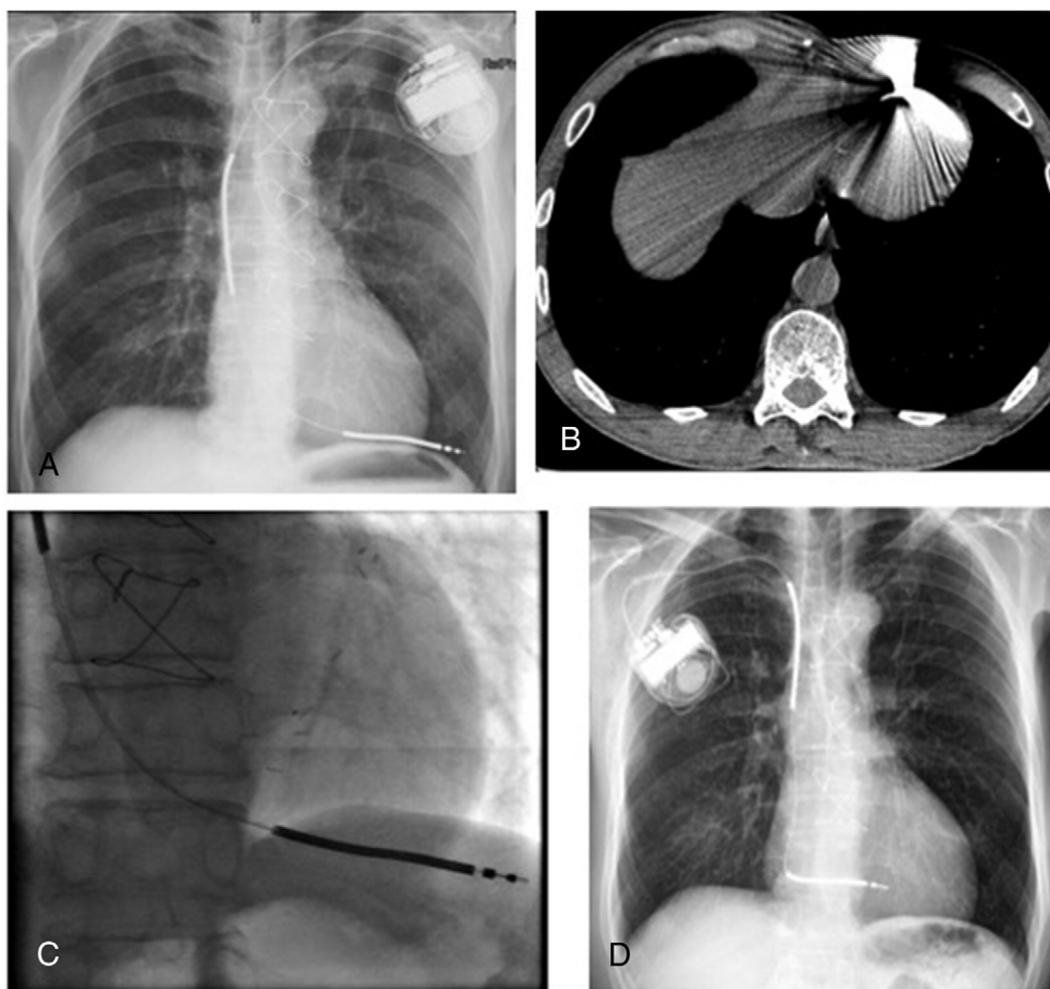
(A) Chest x-ray demonstrating RV perforation by ICD lead. (B) Computed tomography confirmed RV-lead perforation. (C) Fluoroscopy showed displacement of the ICD lead (active fixation), with its tip located outside the cardiac silhouette. (D) The perforating lead was successfully removed by direct traction under fluoroscopy, in the absence of any complications and a new lead was placed.
